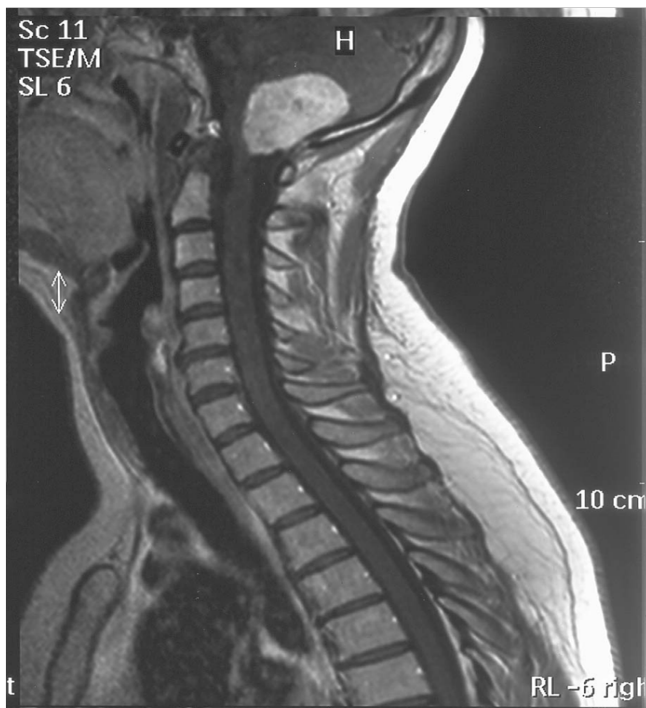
Pre-surgical T1-weighted sagittal MRI with contrast of the C-spine. The large homogeneously enhancing tumor of the posterior fossa is seen but no evidence of leptomeningeal disease or herniated disk at the C5-C6 level. MRI: magnetic resonance imaging
